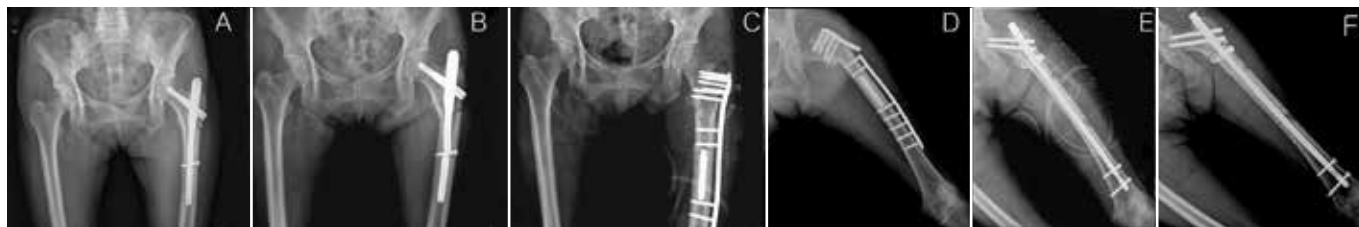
Subtrochanteric fracture in 69-year-old woman. A) Fixation using PFNA. B) Non-union and broken nail developed three months after initial operation. C) Second operation performed with locking plate. The broken distal nail tip remained after removal of the proximal portion of the PFNA. D) Non-union and hardware failure developed six weeks after second operation. E) Anteroposterior view of left femur after nailing. F) Radiograph at 6 months after surgery.
